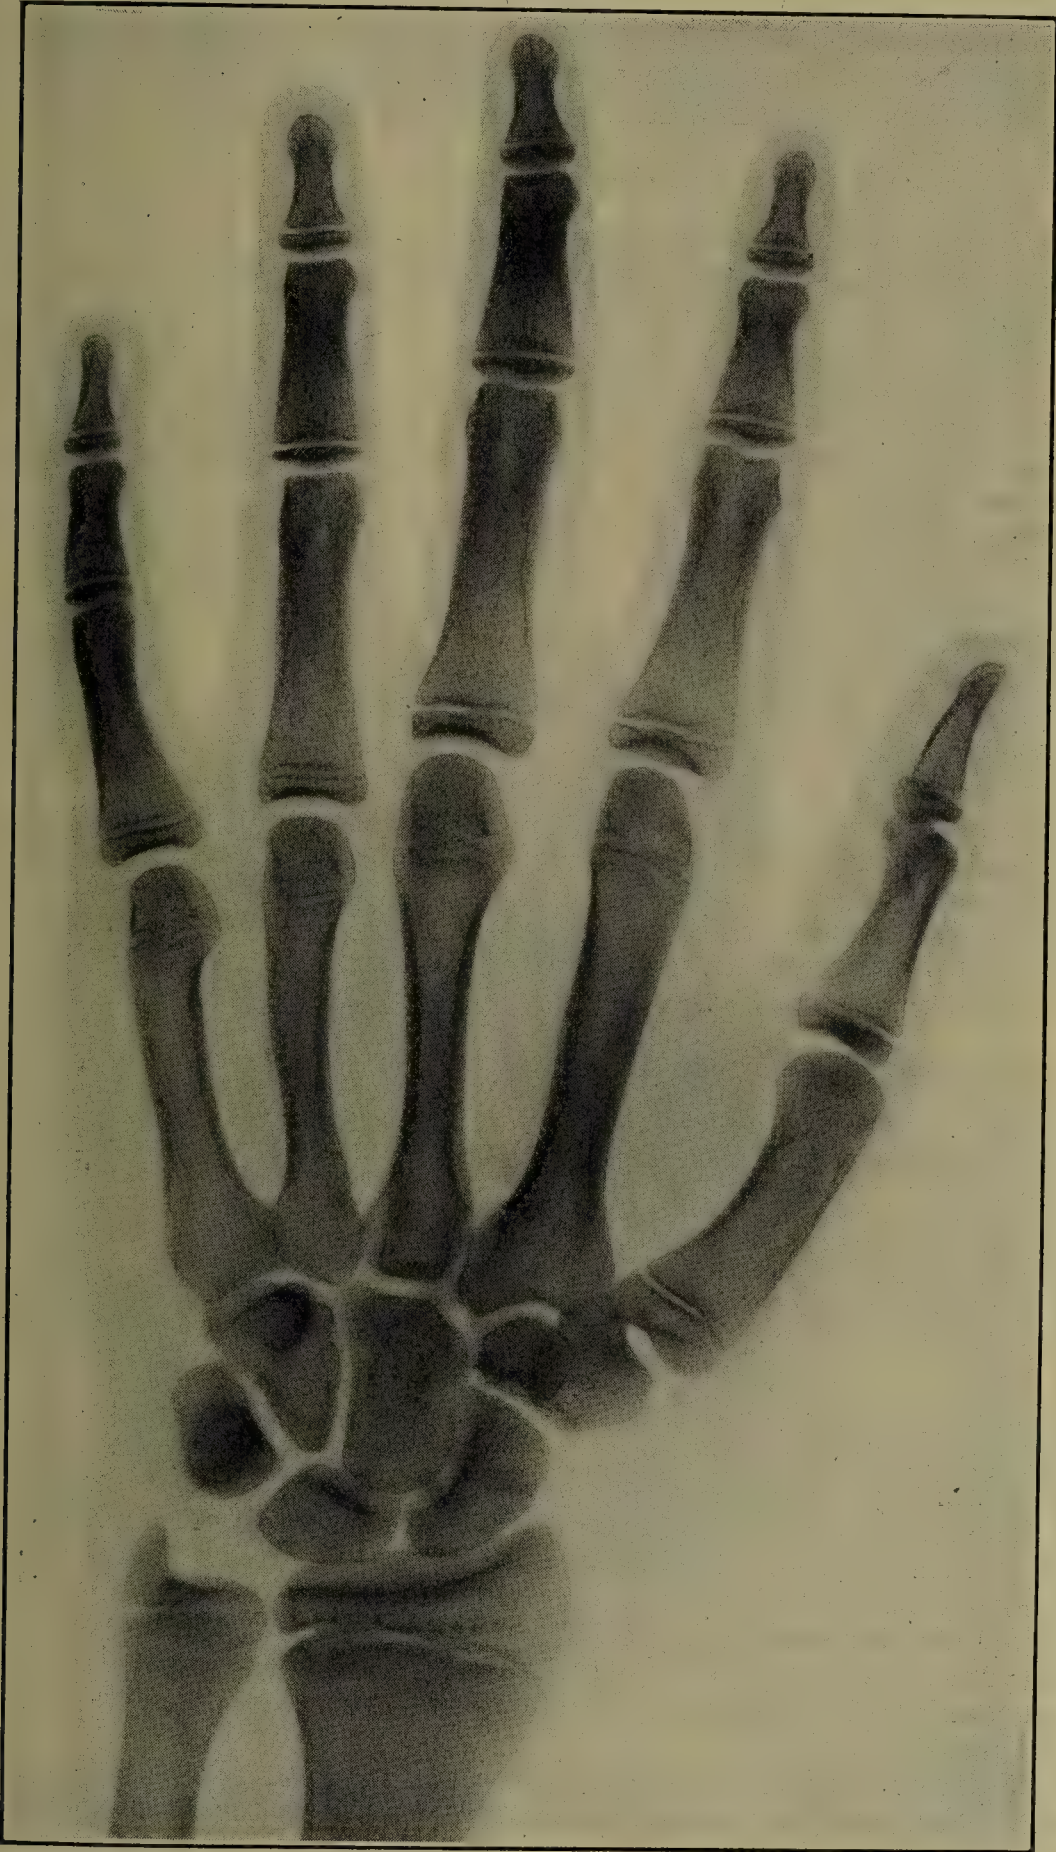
SKELETON OF THE RIGHT HAND OF A BOY AGED 16 YEARS. (From an X-ray plate by Dr. Sherwood Moore, Washington University.)
